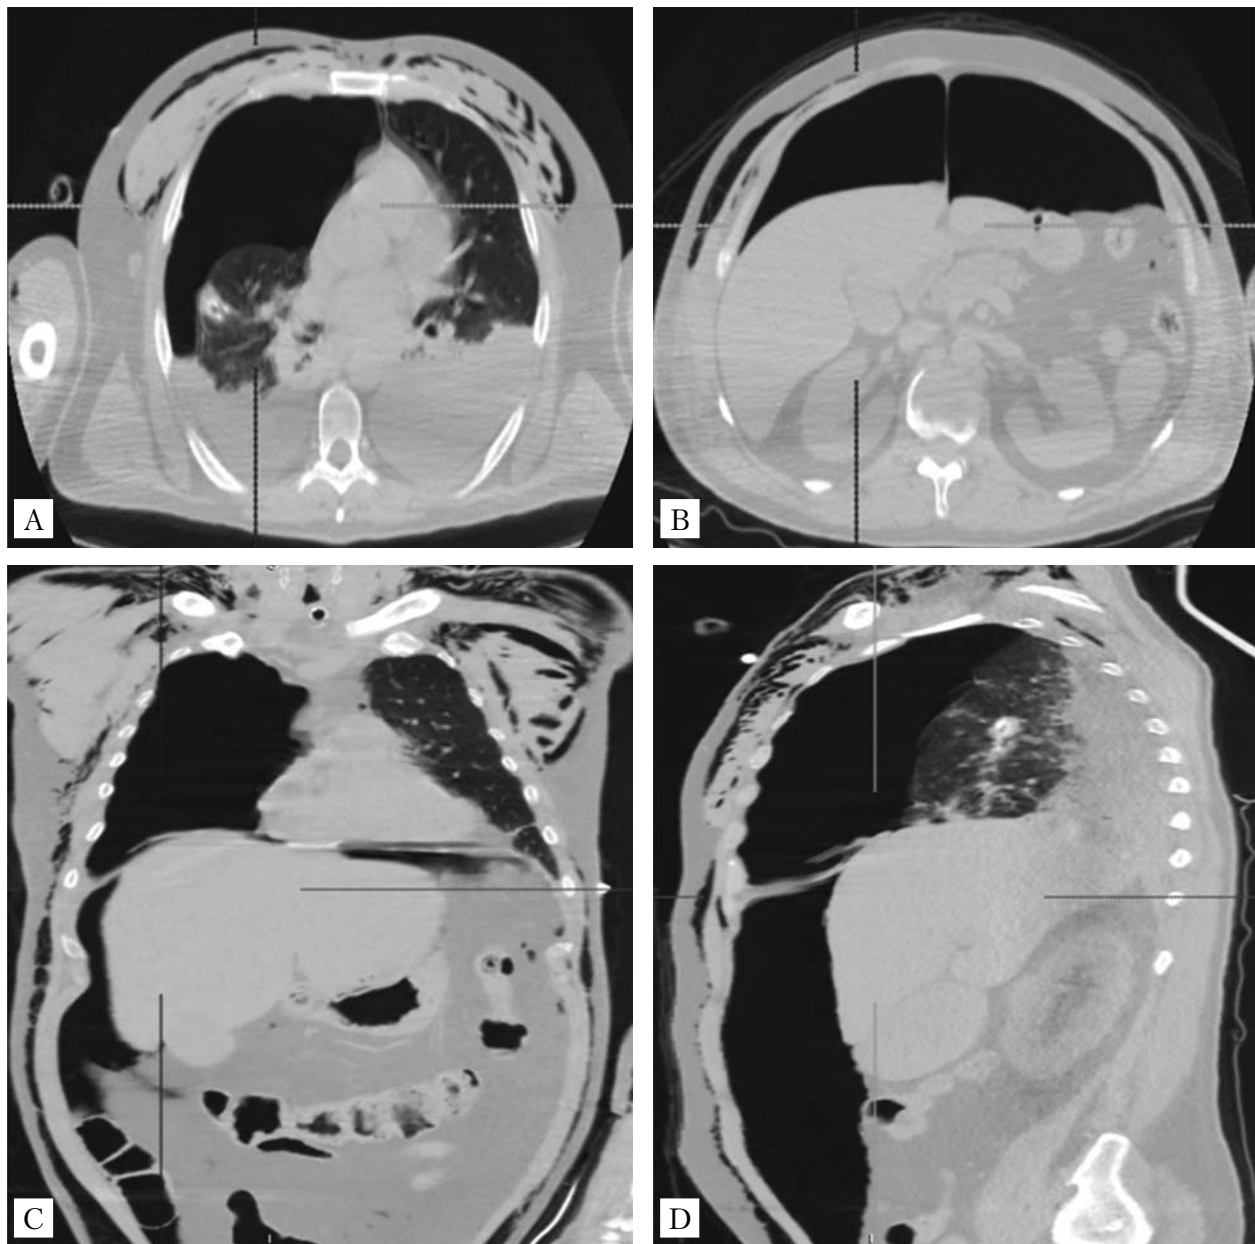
Chest CT scan on the 9th day after injury: A — axial plane: right-sided pneumothorax, bilateral lower lobe pneumonia, soft tissue emphysema; B — axial plane: pneumoperitoneum, soft tissue emphysema; C — frontal plane: right-sided pneumothorax, pneumoperitoneum, soft tissue emphysema; D — sagittal plane: right-sided pneumothorax, pneumoperitoneum, soft tissue emphysema
